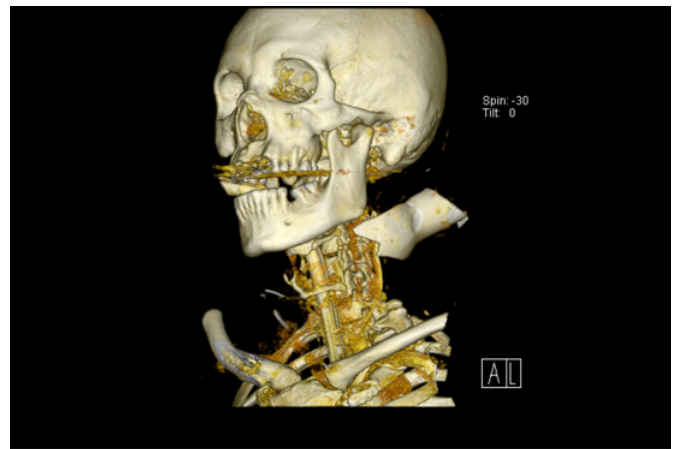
CT 3 dimensional reconstruction.
